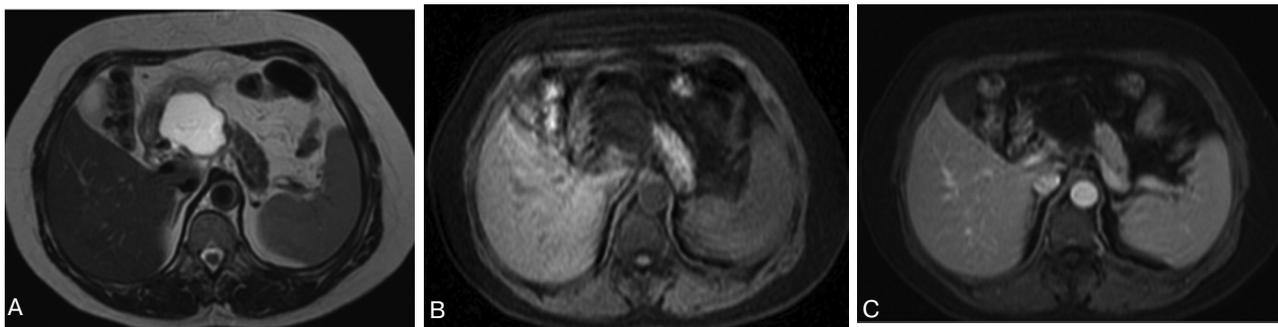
MRI of mucinous cystadenoma. A. Axial T2-weighted MR image shows wellcircumscribed hyperintense lesion in the head of pancreas. B and C. The lesion has low signal intensity on unenhanced T1-weighted MR image (B) and does not contain enhancing solid components (C)
